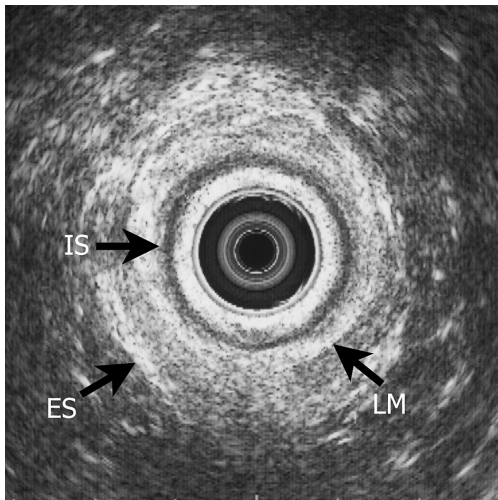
Transverse endoanal ultrasonography at the mid-anal canal obtained from a 65-years-old man demonstrating normal anatomy at the mid-anal canal of the internal anal sphincter (IS), longitudinal muscle (LM), and external anal sphincter (ES). The top of the figure is anterior.
